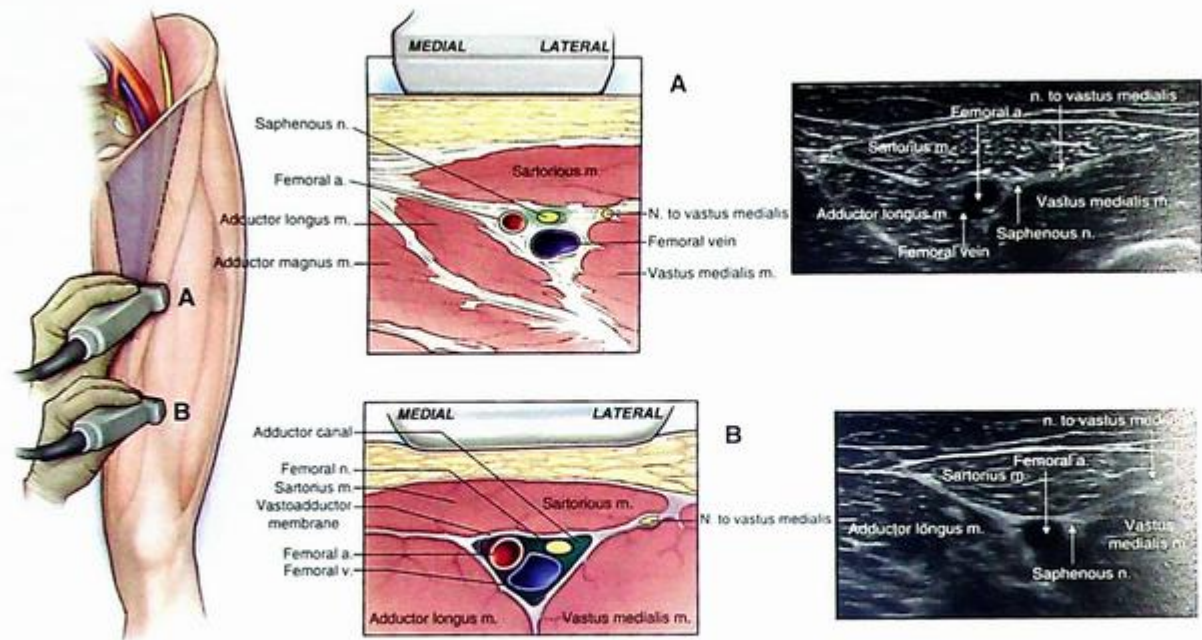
Sonography of (A) femoral triangle and (B) adductor canal.
